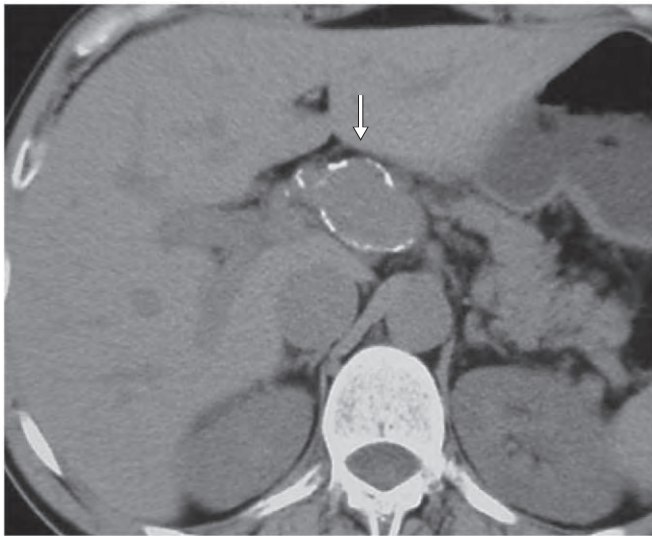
CT demonstration of a large, solitary, calcified hepatic artery aneurysm (arrow).
